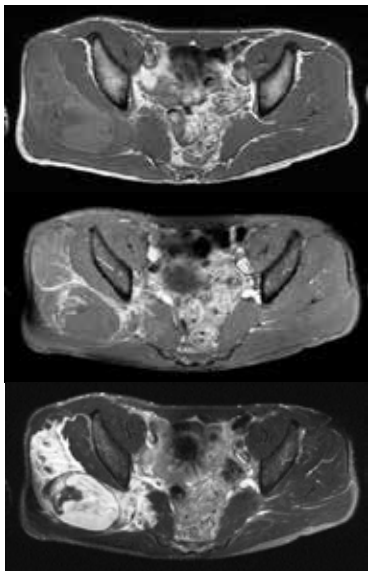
demonstrated MRI axial T1W, T1W with Gadolinium (Gd) and T2W fat suppression view respectively.
